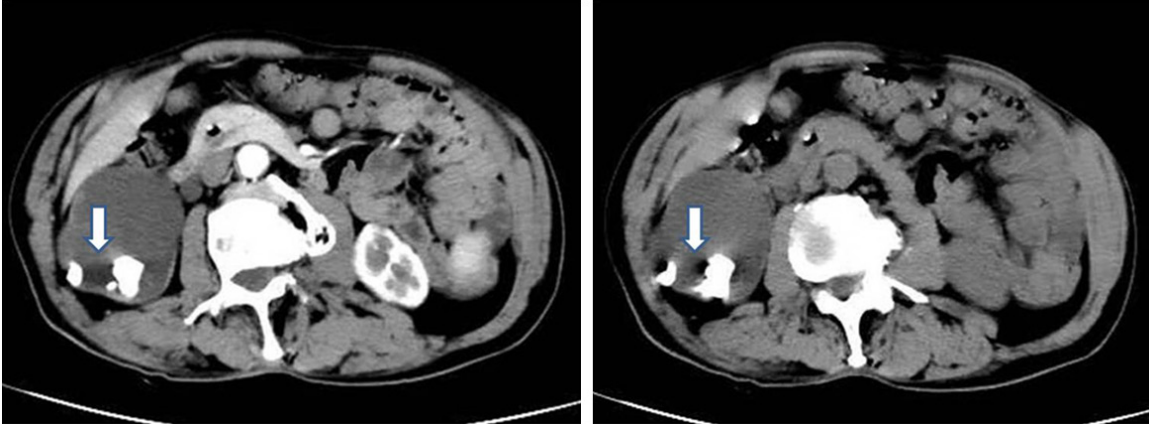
Computed tomography (CT) of the abdomen showed that the right renal pelvis, caliceal dilated and hydronephrosis formed; multiple patchy consolidations with high density were seen in renal pelvis (arrowhead point).
